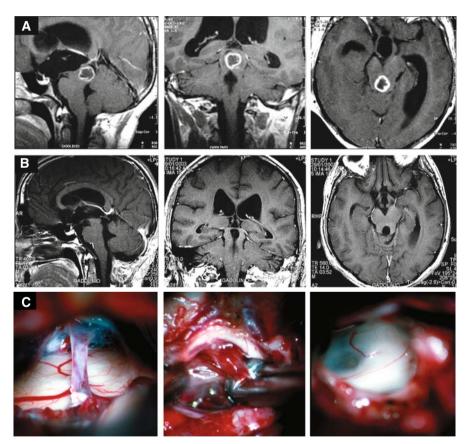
20-year-old man presenting with oculomotor disturbances, headache, ataxia and papilledema. The tectal benign astrocytoma shown on MR images (A) was radically removed (B) via an infratentorial supracerebellar approach. The intraoperative views (C) show the swollen quadrigeminal plate bulging ventrally to the cerebellum with its central vein, which was sacrificed. By entering below the plate, the dorsal aspect of the tumor is exposed, freed a little at a time, and then completely removed with consequent resolution of the hydrocephalus. The patient had a favorable course with disappearance of the neurological disturbances
